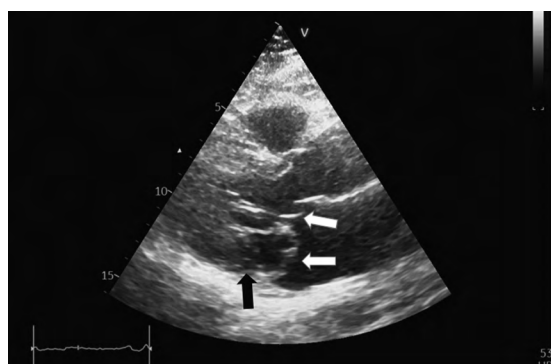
Parasternal long-axis view of the left ventricle. Systole. White arrows indicate elongated and thickened mitral valve leaflets prolapsing into the left atrial cavity. The black arrow indicates the disjunction area
